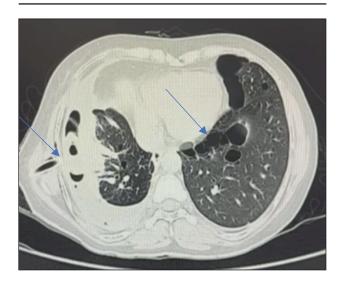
CT-thorax showing right-sided hydropneumothorax and lenticular elongated cysts in the para mediastinal areas.
